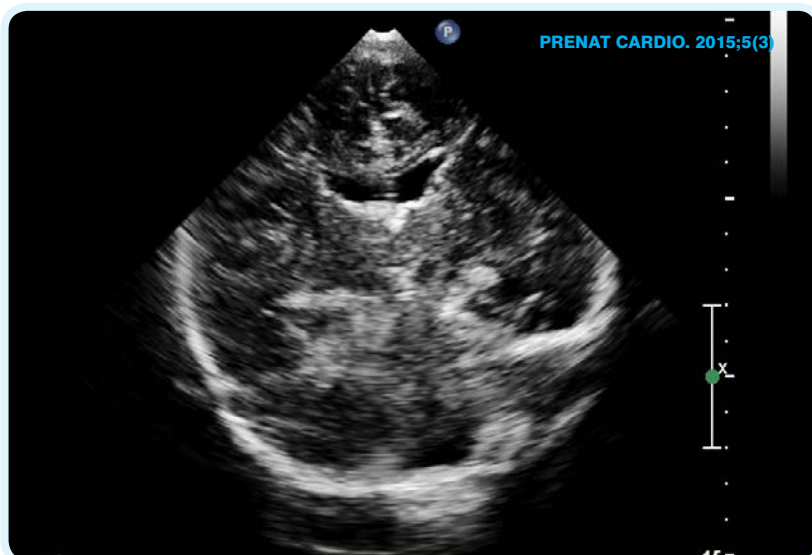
The cranial ultrasound at 7 months after prenatal and postnatal decompression of the cyst.
